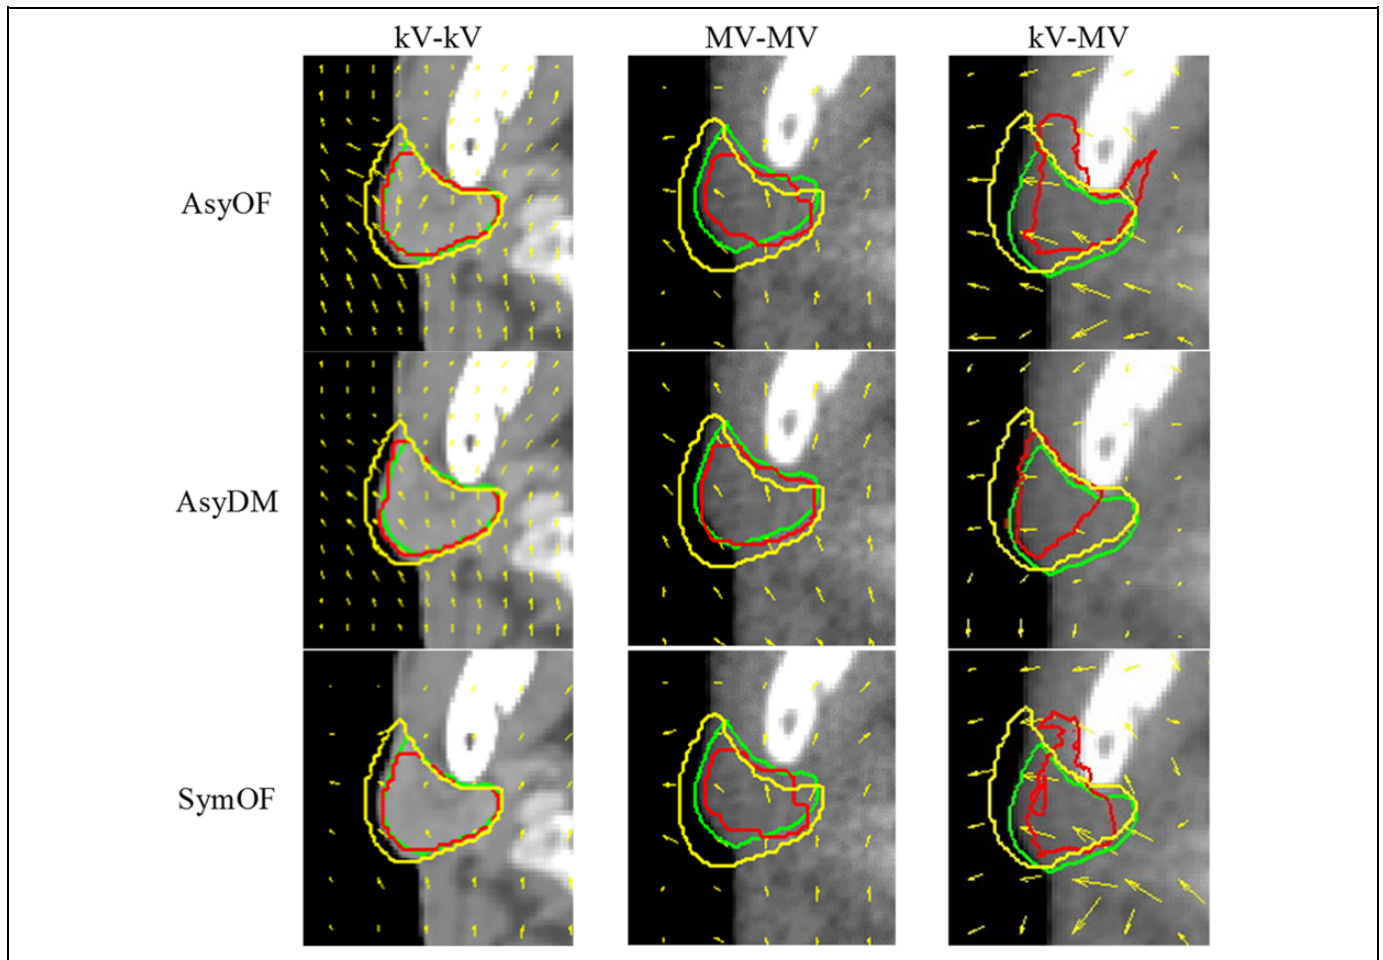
The automatic deformed images of the right parotid gland (red) deformed from the original contour (yellow), in comparison with the reference contour (green) in 1 nasopharyngeal carcinoma (NPC) case for kilovoltage computed tomography (kVCT) and megavoltage computed tomography (MVCT) image procedures in kV-kV, MV-MV, and kV-MV by asymmetric with optical flow (AsyOF), asymmetric transformation with the demons algorithm (AsyDM), and symmetric with the Horn and Schunck optical flow (SymOF) deformable image registration (DIR) methods.
